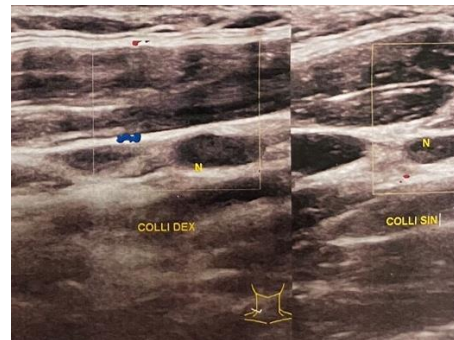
Thyroid ultrasound showed mass, swelling, and calcification
